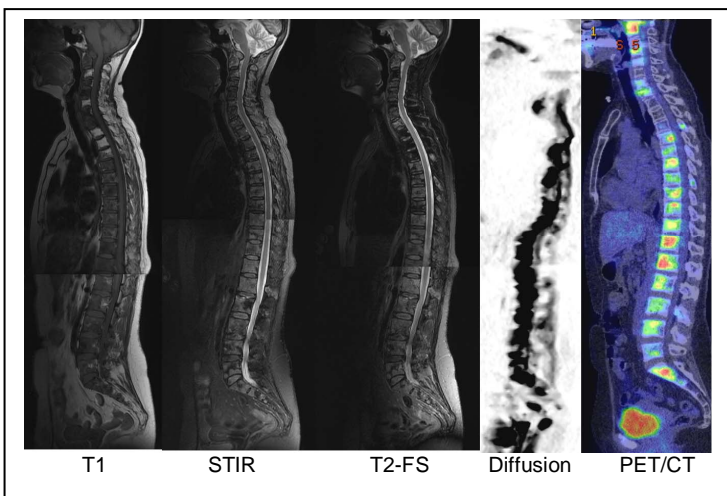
Number of bone metastases on MRI compared with PET/CT.
